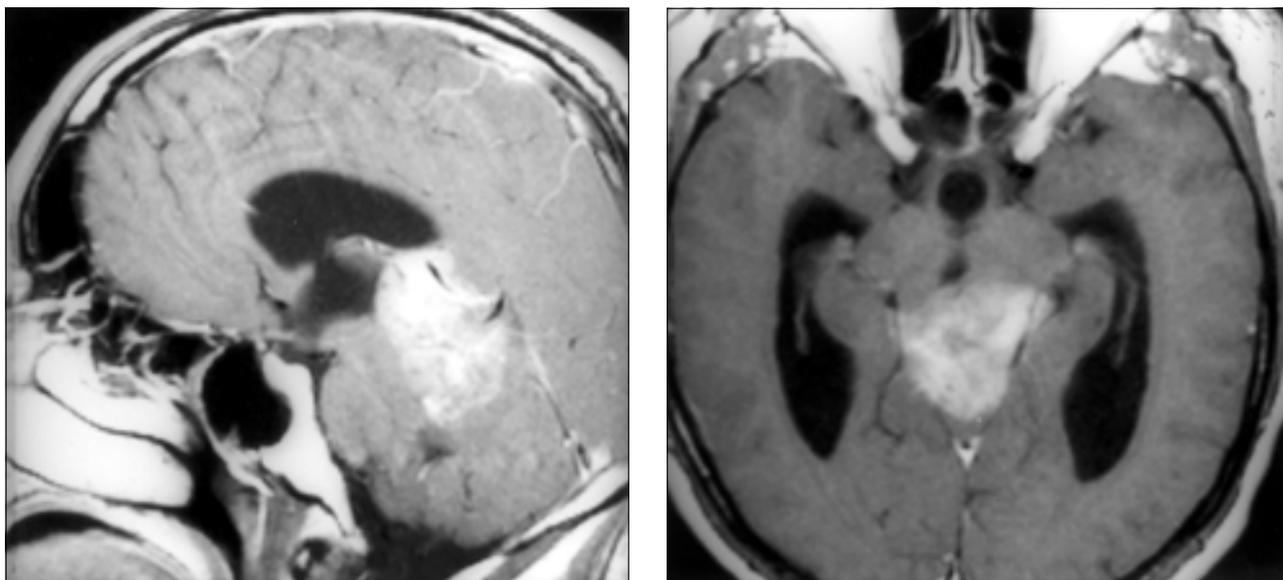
MRI 4 weeks after onset of symptoms showed an inhomogenous tumor of the pineal gland.
